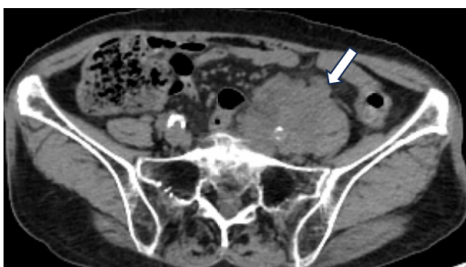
Plain CT scan image.
